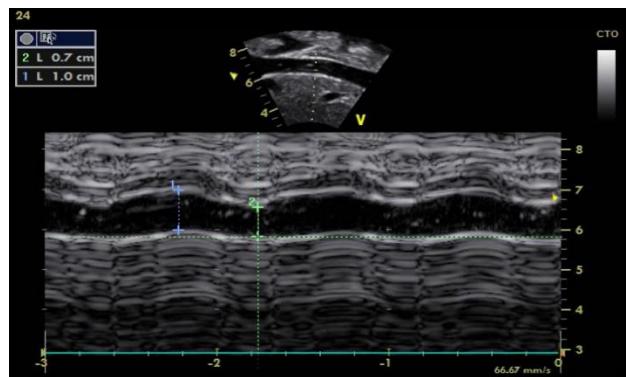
M-mode echocardiogram of inferior vena cava (IVC) showing an IVC partially collapsing with respiration.
